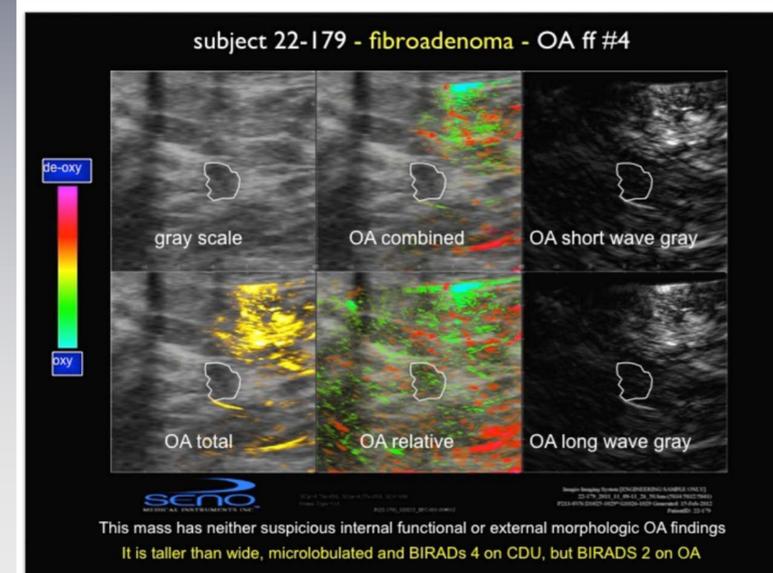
A taller than wide suspicious solid lesion on ultrasound, with no suspicious internal or external functional morphologic opto-acoustic findings. Read as a BIRADs4 on ultrasound, this was a fibroadenoma on biopsy
